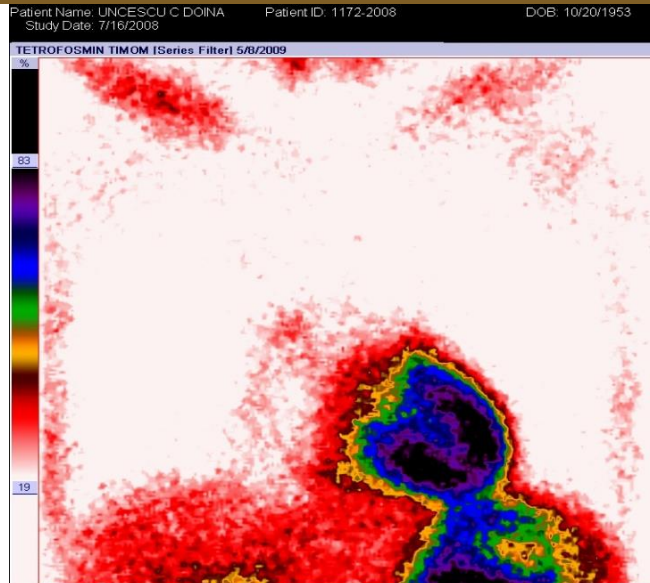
Preoperative thymic scintigraphy
